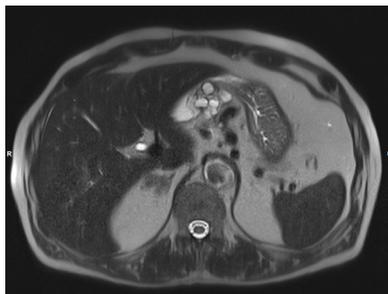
Abdominal magnetic resonance imaging showing a 60 × 50 mm multiloculated gastric cystic lesion in the lesser curvature.
